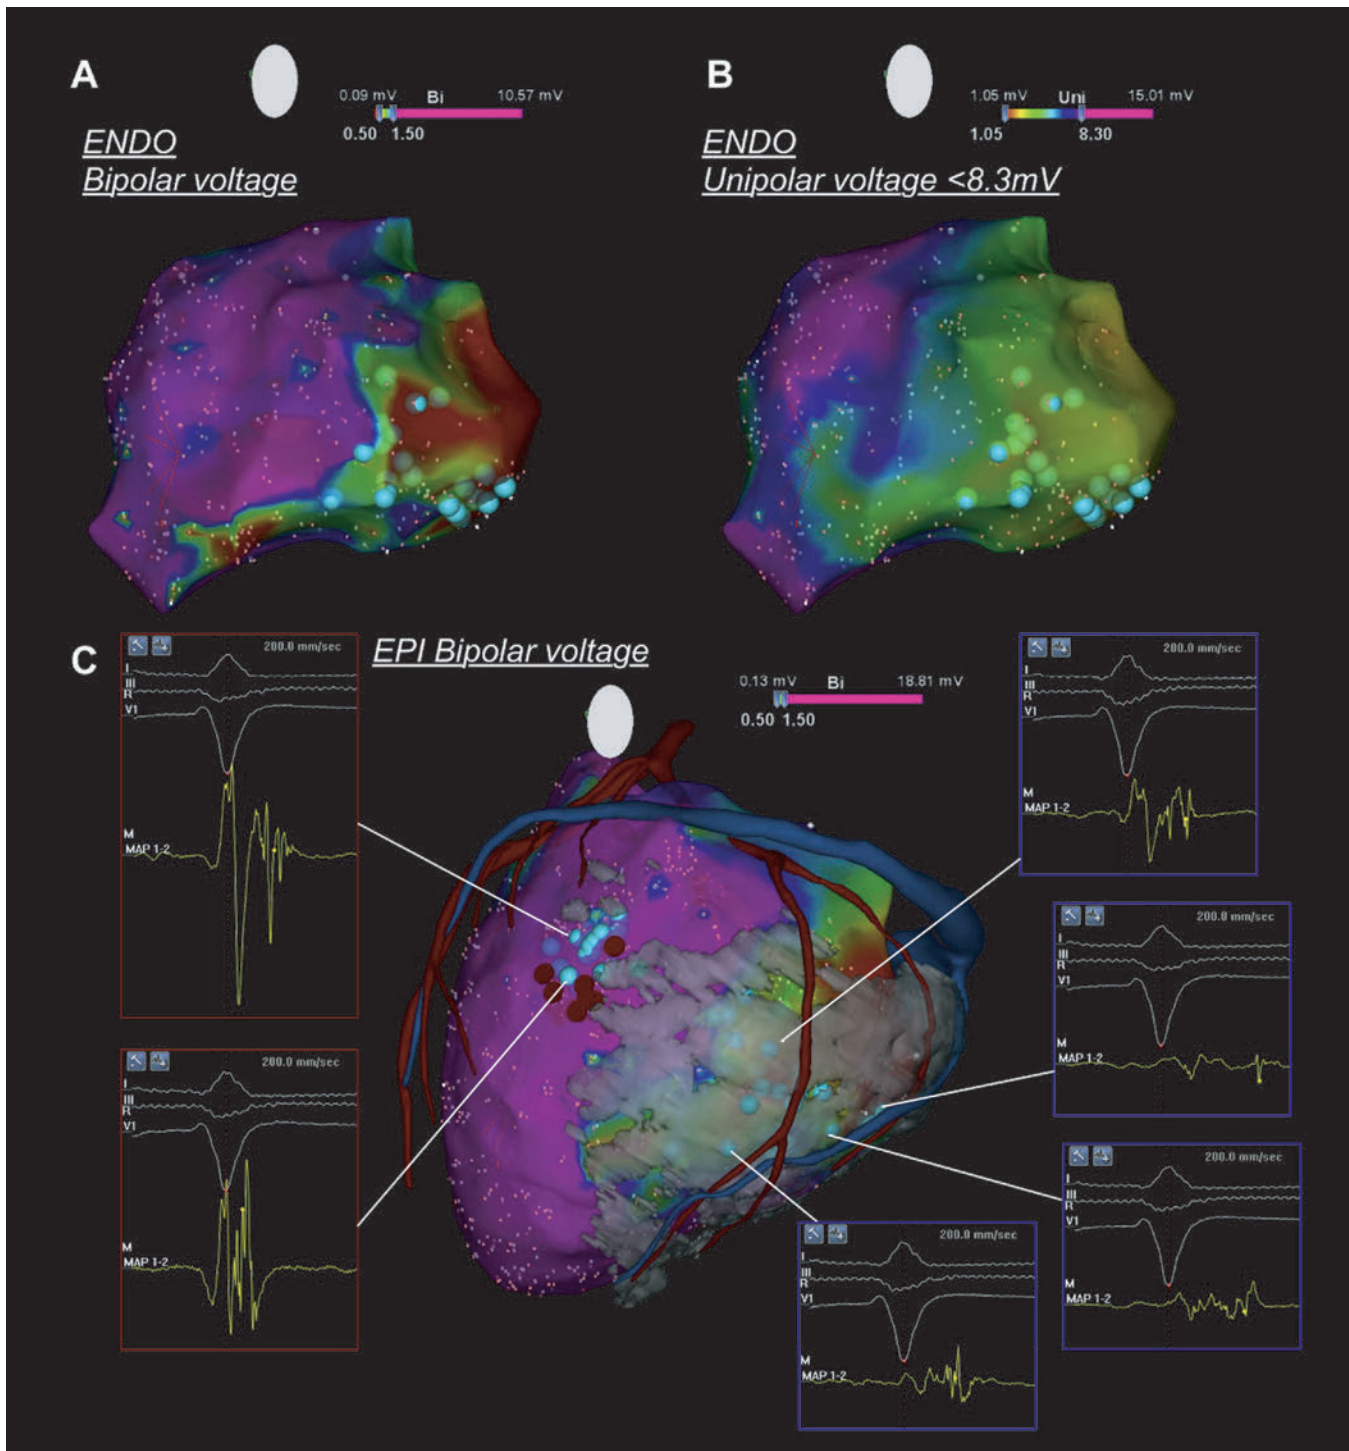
Endocardial (ENDO) and Epicardial (EPI) Voltage Map With Wall Thinning Segmentation in Patient With Ischemic Cardiomyopathy. (A) Endocardial bipolar voltage map shows low voltage with the presence of local abnormal ventricular activity (LAVA, light blue dots) at the basal posterolateral left ventricle. A peak-to-peak bipolar amplitude less than 1.5 mV is defined as low voltage, and less than 0.5 mV is defined as dense scar. (B) Endocardial unipolar voltage map is shown. A unipolar amplitude of less than 8.3 mV is defined as abnormal voltage. (C) Epicardial bipolar voltage map merged with the multidetector computed tomography model shows the location of low-voltage area and LAVA corresponding to the wall thinning segmentation (white area). Endocardial ablation successfully eliminated the posterolateral LAVA (in blue box), which had the following characteristics: low bipolar amplitude; location within the wall thinning segmentation; opposite endocardial low unipolar voltage; and presence of LAVA at the opposite endocardium. On the contrary, epicardial LAVA located mid-anteriorly (in red box) could not be eliminated by endocardial ablation and needed to be ablated epicardially. They were of higher bipolar voltage (>1.5 mV), located outside the wall thinning segmentation, and opposite endocardium with higher unipolar amplitude. (From Komatsu Y, Daly M, Sacher F, et al. Endocardial ablation to eliminate epicardial arrhythmia substrate in scar-related ventricular tachycardia. *J Am Coll Cardiol*. 2014;63:1416–1426.)
